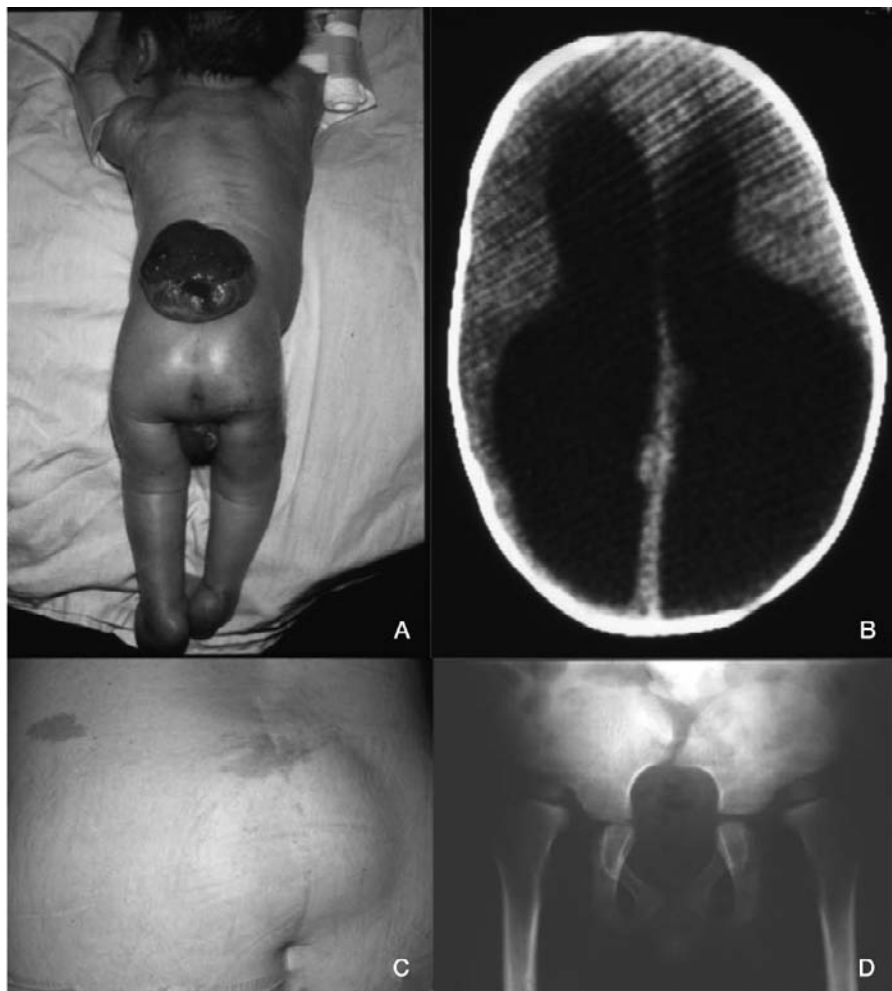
(A) Lumbar myelomeningocele; (B) computed tomography showing a hydrocephalus; (C) lipomyelomeningocele (sacral lipoma); and (D) radiograph demonstrating a sacral agenesis.
